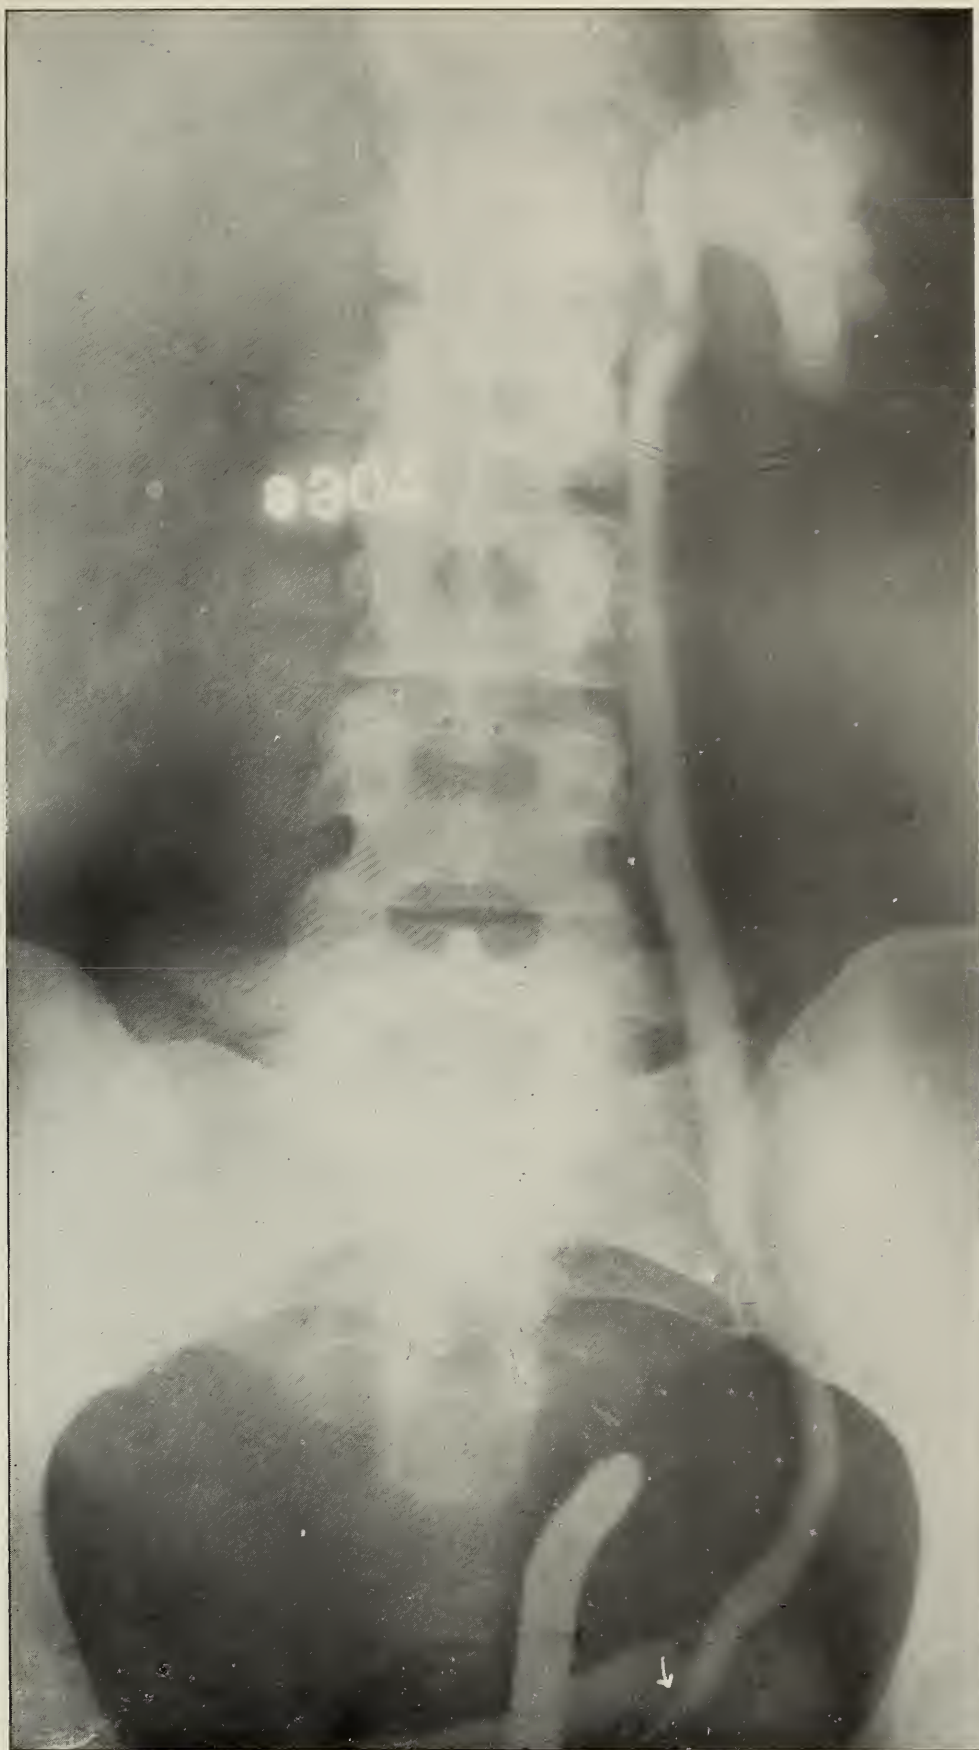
X-ray No. 9304. Region: abdomen and pelvis. Uniform moderate dilatation of left ureter throughout its entire length with small hydronephrosis. Obstruction present at ureteral-vesicular junction. Shadow on original plate present at this point. Diagnosis: small ureteral stone. Not operated.
